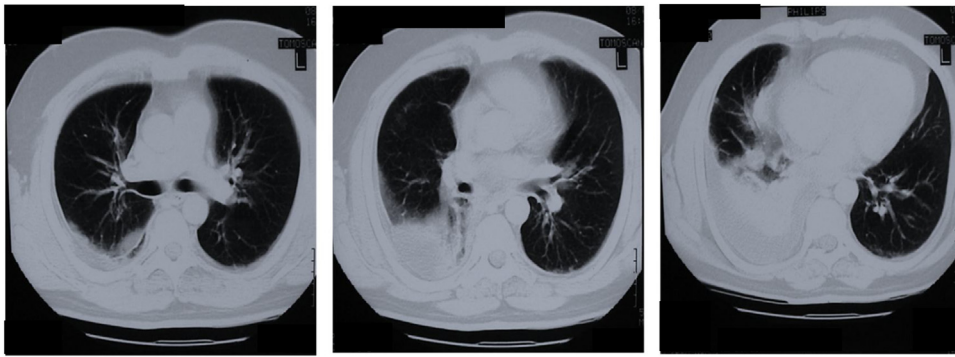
Chest CT: Right lung base consolidation.
